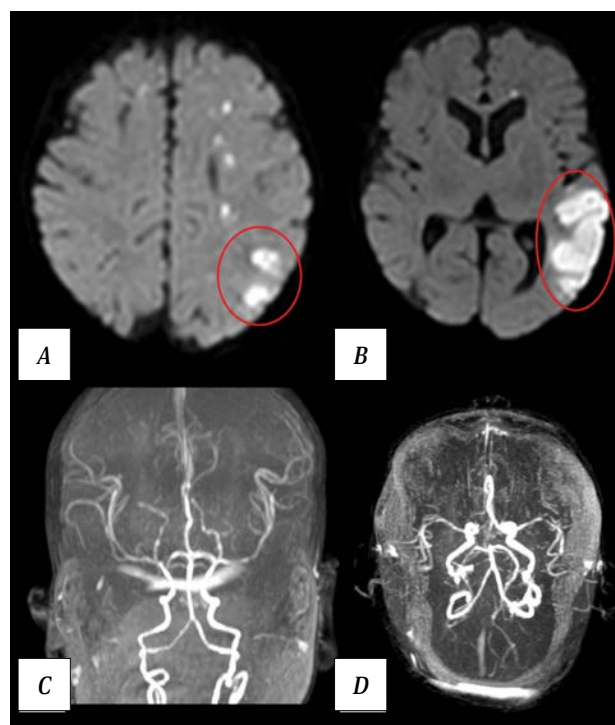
Results of patient V. MRI on day 2 postoperatively. A, B – brain MRI. Right DWI, axial plane. Watershed infarction zone in the left cerebral hemisphere (red ovals), multiple small ischemic foci. C, D – MR angiography, 3D reconstruction. Intracranial arterial blood flow remains intact.
